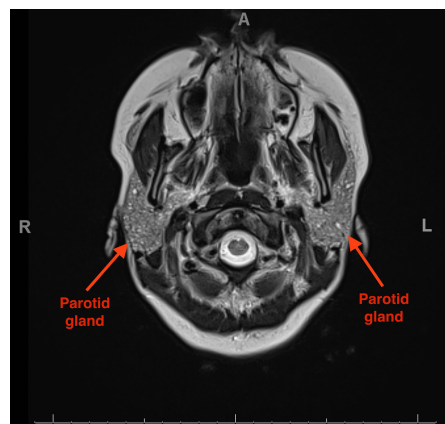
MRI brain without contrast.
